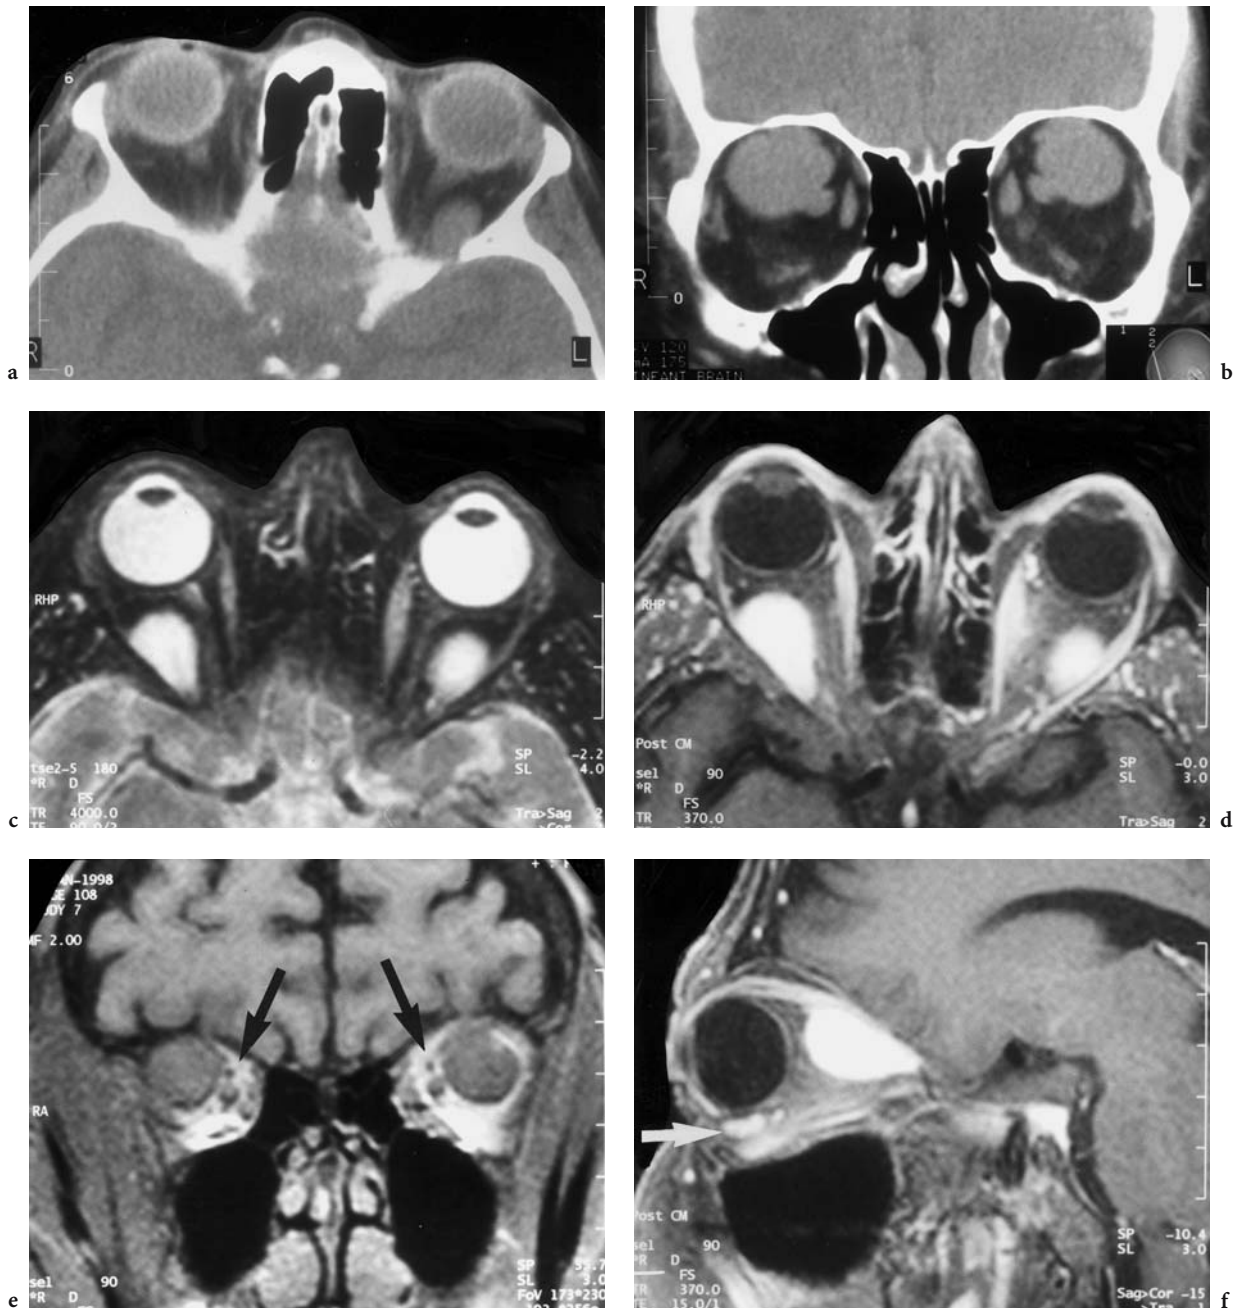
A 67-year-old woman with recurrent, painless, bilateral orbital protrusion, which is more pronounced on bending down. Diagnosis: orbital venous anomaly. CT: a Axial view of the upper orbit showing a sharply defined, oval formation in the left superior orbit adjacent to the orbital apex. b Coronal view demonstrating clearly defined lesions of different sizes in the lateral muscle cone between the lateral rectus and the superior oblique muscle in close vicinity to the medially dislocated optic nerve. The different sizes result from the prone position of the patient with consecutive increase of intraorbital pressure. MRI: c Axial T2-weighted view, corresponding to a with hyperintense, bilateral, intraconal lesions lateral of the optic nerve. d Corresponding axial, T1-weighted, contrast-enhanced (FS) image where the enlarged veins exhibit a homogeneous signal enhancement. e Coronal T1-weighted native view corresponding to b, demarcating the well-defined vascular formation with medial and inferior dislocation of the optic nerve. Note the normal diameter of both medially dislocated superior ophthalmic veins (*arrows*). f Sagittal, T1-weighted, contrast-enhanced (FS) view with homogeneous signal enhancement of the orbital varices, reaching and molding the orbital apex. Note another small varix in the inferior extraconal area (*white arrow*)
